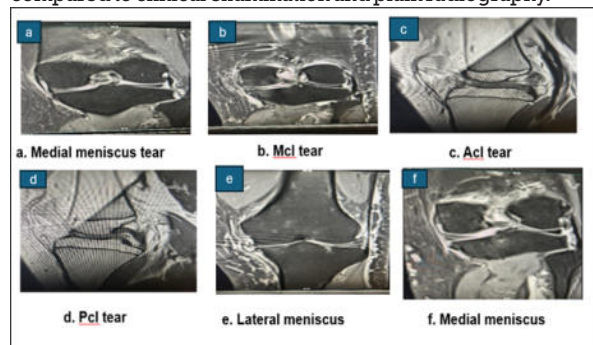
Clinical Findings Vs MRI Findings
